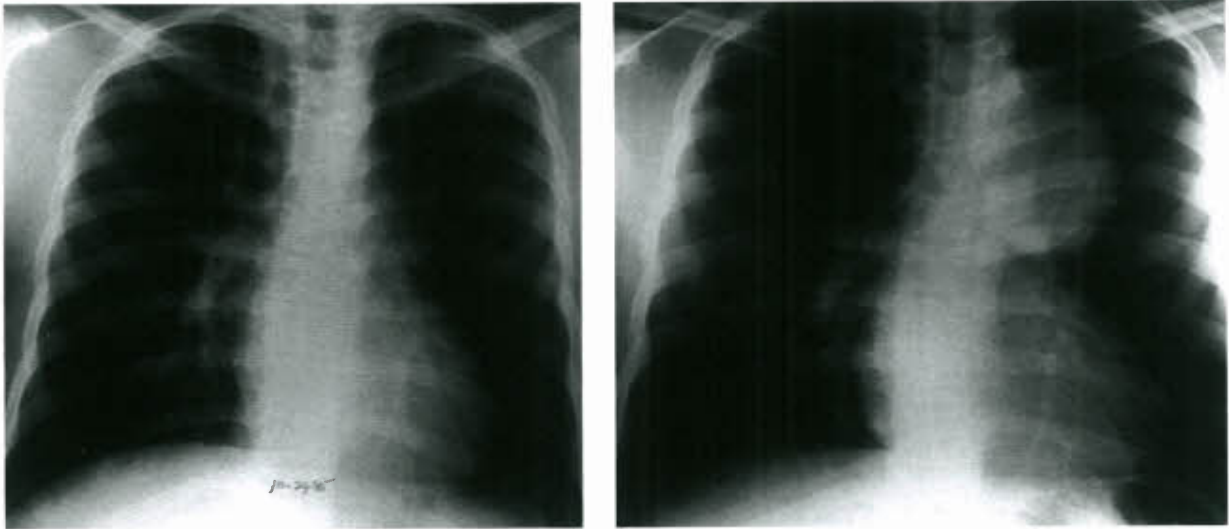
Chest radiograph 3 years (left panel) and 8 years (right panel) after prosthetic patch aortoplasty repair of coarctation, documenting progressive aneurysmal dilation at the repair site. (Reprinted from Mendelsohn AM, Crowley DC, Lindauer A, et al. Rapid progression of aortic aneurysms after patch aortoplasty repair of coarctation of the aorta. *J Am Coll Cardiol* 1992;20:381–385, with permission from Elsevier.)
